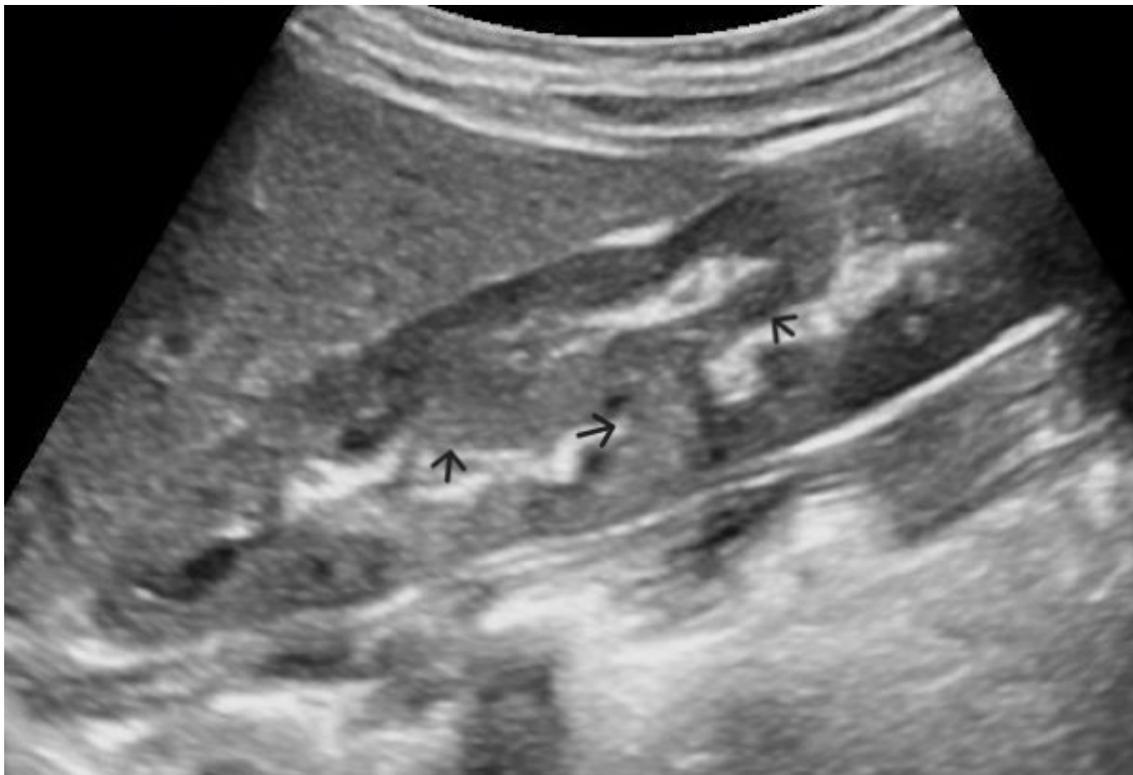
Ultrasound image of the right kidney (sagittal scan) shows three columnar masses (arrows) crossing the sinus and giving an appearance of a trifid renal sinus.
